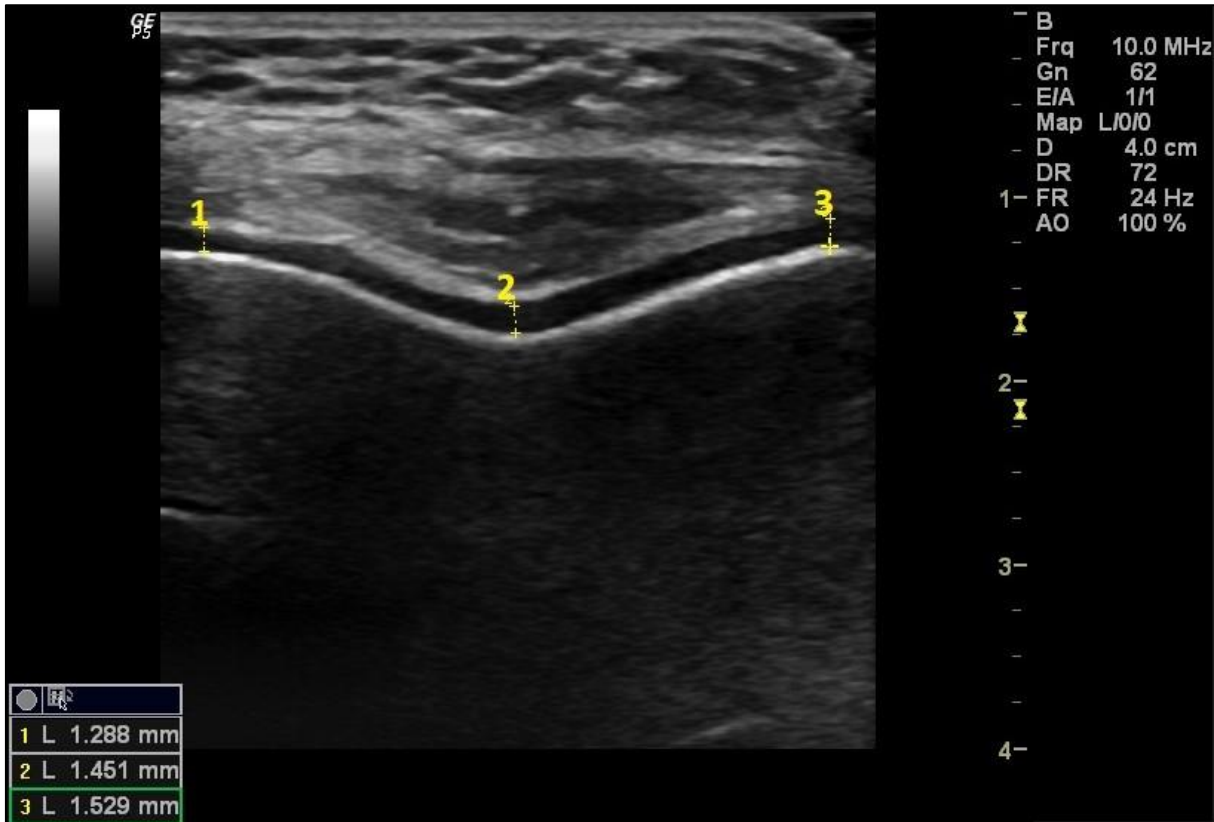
Ultrasonographic measurement of distal femoral cartilage thickness; medial (1), intercondylar (2) and lateral (3) femoral cartilage thickness
